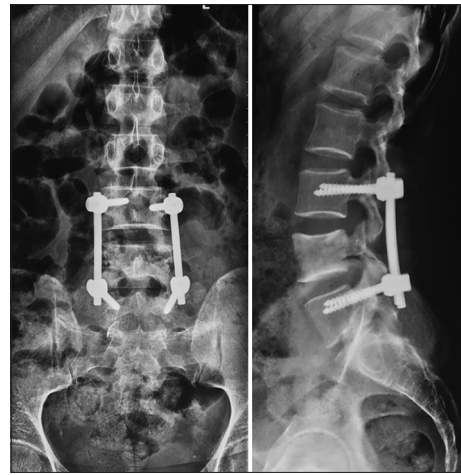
Postoperative X-ray at 1 month follow up showing the implants *in situ* without further collapse of L4
